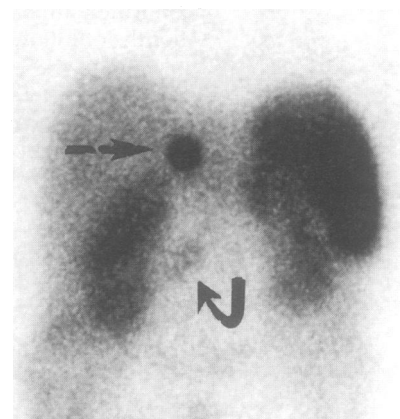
Second SRS in patient 5 (table 5) showing a well delineated hot spot in the left liver lobe (CT normal) (arrow) and another hot spot in the duodenopancreatic area (curved arrow) probably corresponding to a pancreatic head tumour.
